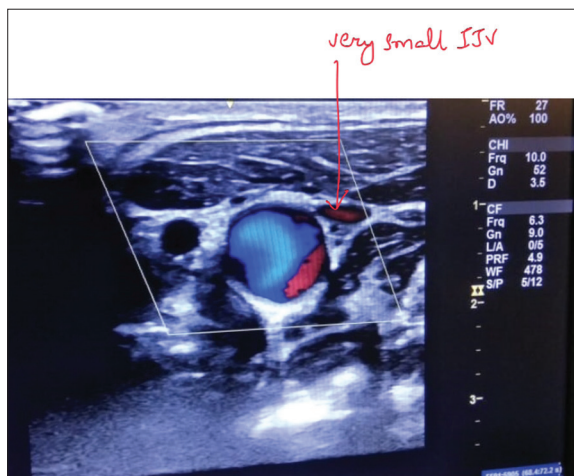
Ultrasonographic image of showing a small sized internal jugular vein and carotid artery
